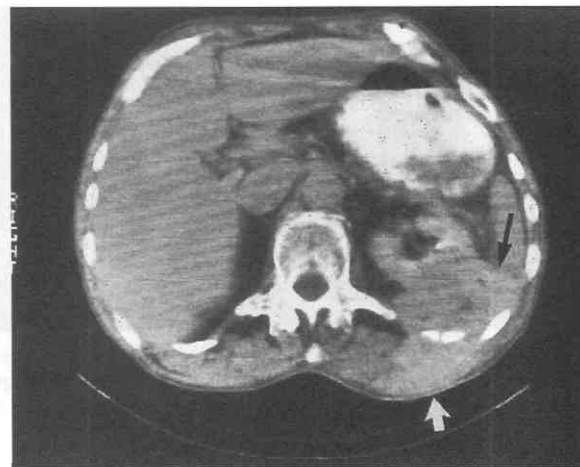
Renal parenchymal malacoplakia. CT scan shows a nonspecific soft tissue mass (black arrow) extending from the left kidney and invading the perinephric space and the left flank (white arrow). (Courtesy of David S. Hartman, M.D., Hershey, Pa.)
